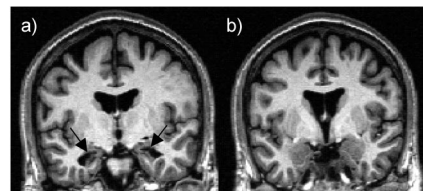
MRI of patient W.S. Two coronal sections of a T1-weighted structural scan obtained at the level of the anterior hippocampus (a) and amygdala (b). Arrows in Panel a indicate selective bilateral atrophy of the hippocampus proper.
